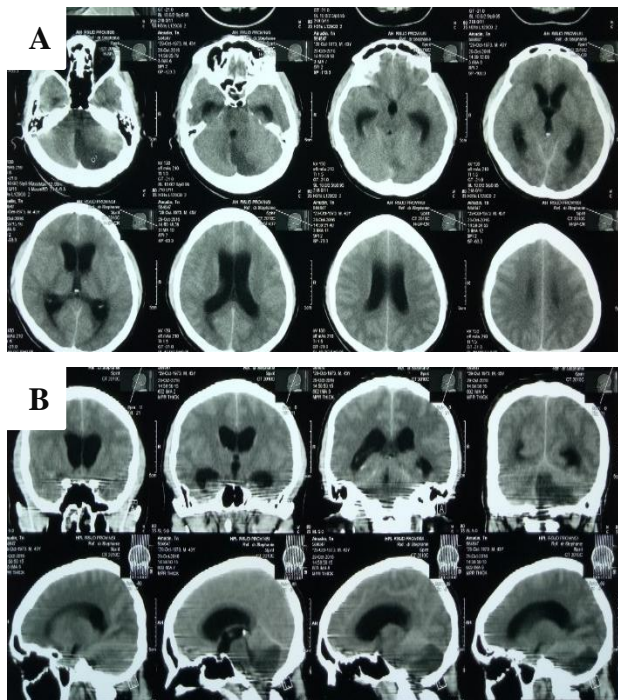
Head CT scan with contrast. A) Axial section. B) Coronal-sagittal section: obstructive hydrocephalus and infarct area in left cerebellar hemisphere.
